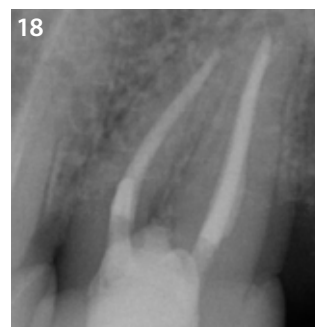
Final X-ray inspection
